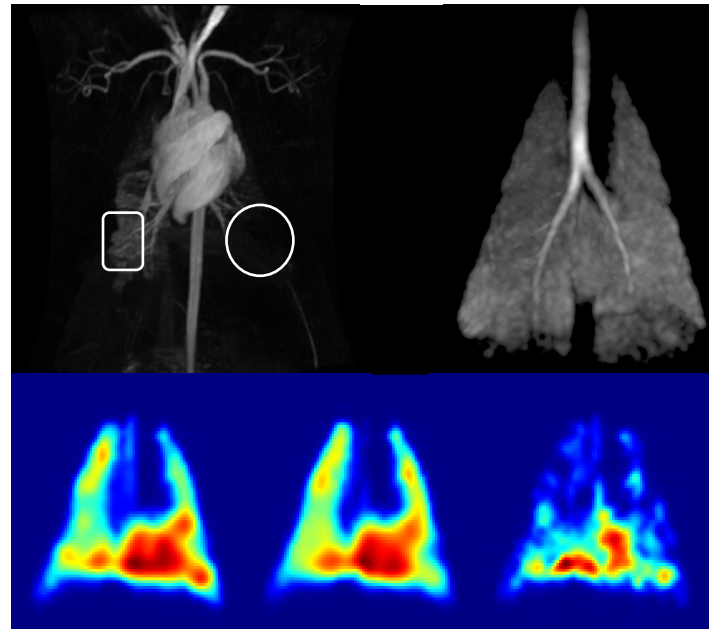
Top row: Dynamic contrast enhanced (DCE) MRI of pulmonary blood flow, note embolized area bottom right in the lungs (white circle) and normally perfused area (rounded square); Top right: Ventilation distribution of ^{129}Xe . Bottom row, dissolved phases from left to right: gas, barrier, and red blood cell.
